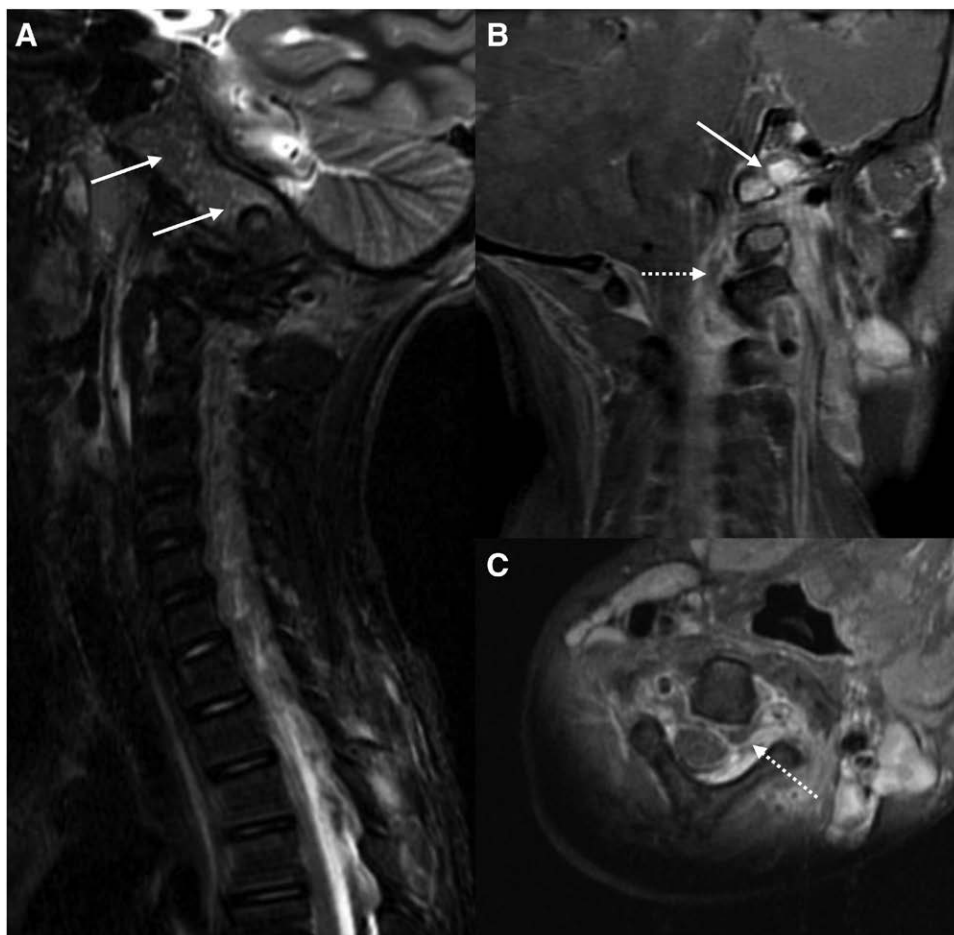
Magnetic resonance imaging (MRI) of the cervical region. Left sagittal T2 STIR (A); oblique coronal T1 post-contrast (B); axial T1 post-contrast (C) demonstrating clival and exoccipital edema (solid arrow) and enhancement, left epidural abscess (dashed arrow) and left paraspinal myositis. STIR indicates short tau inversion recovery.
